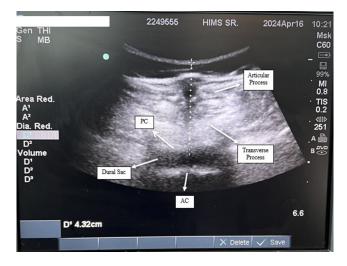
Ultrasound image in transverse plane. Midline bright hyperechoic ("=" sign) structure represent the posterior complex (PC) and anterior complex (AC)
